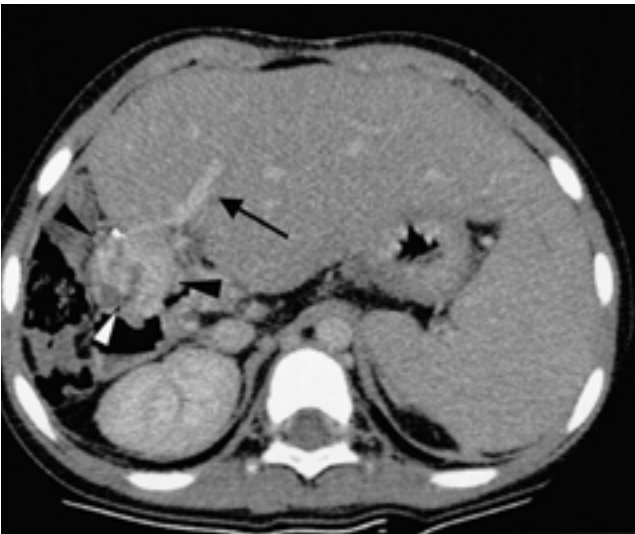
Enhanced CT shows multiple collateral vessels adjacent to the portal vein anastomosis. Intrahepatic portal vein is patent.
